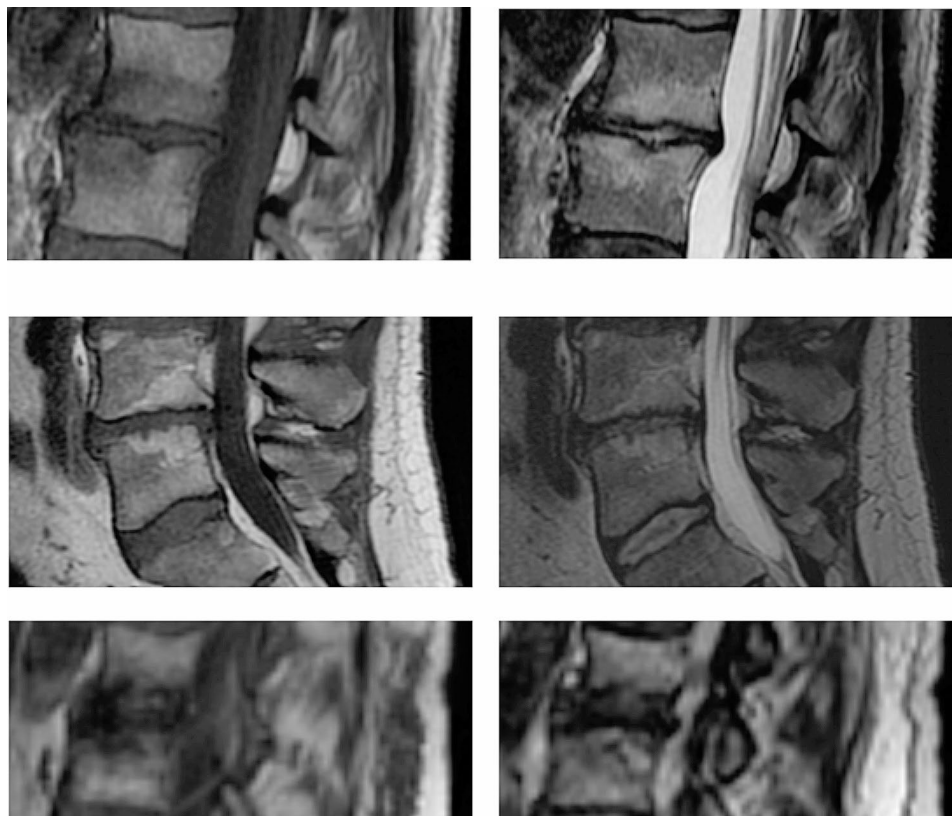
Endplate degeneration (ED) in the lumbar spine. Sagittal MRI (T1- [left] and T2-weighted [right]) images of the lumbar spine. Grade 1 (top), grade 2 (middle) and grade 3 (bottom) of ED
